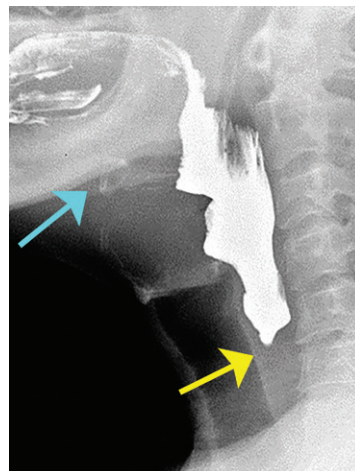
Delayed opening of the PES due to retarded relaxation of the UES in a 71-year-old woman. Lateral radiograph shows the bolus tip at the PES entrance, which remains closed (yellow arrow), even when the hyoid bone is fully elevated (blue arrow). On subsequent images (not shown), the PES opened completely, allowing the full passage of the bolus.
